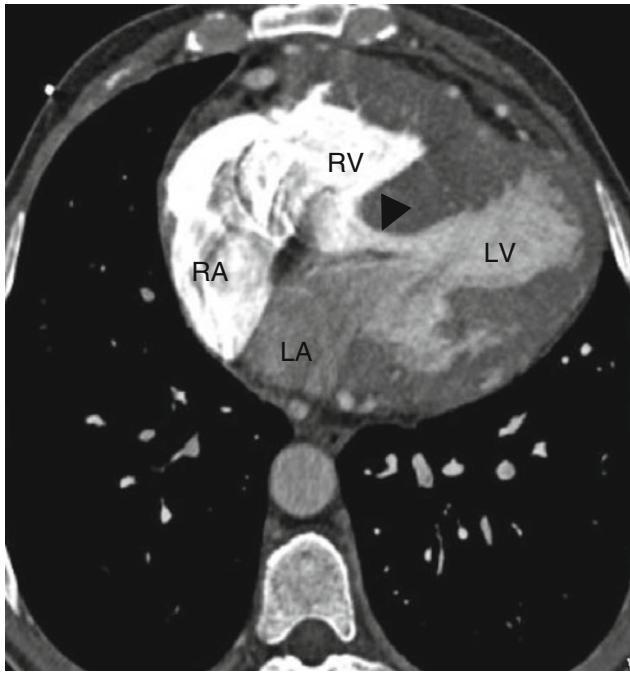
Ventricular septal defect (VSD) in a patient with pulmonary atresia and VSD. This axial CT shows a large subaortic (membranous) type VSD (arrowhead)
